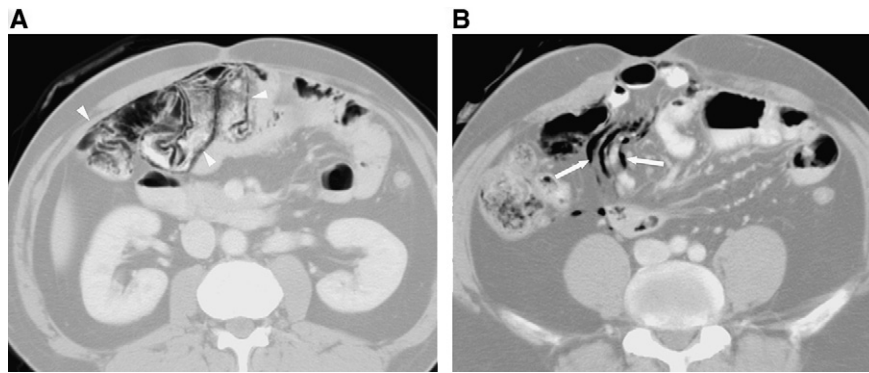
Incidental detection of pneumatosis intestinalis in a patient receiving systemic chemotherapy for enteropathy-associated T-cell non-Hodgkin lymphoma. (A) Axial computed tomographic (CT) images of the mid abdomen, demonstrating extensive pneumatosis intestinalis (arrowheads) within multiple loops of small bowel. (B) An inferior-section CT image, showing air tracking along the mesenteric vessels (arrows).
